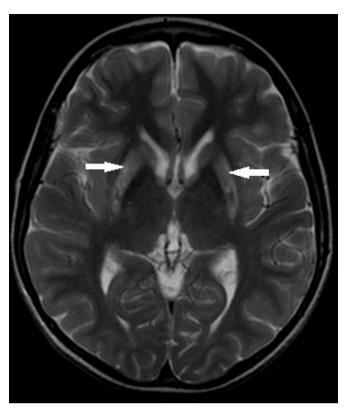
T2-weighted MRI brain image: arrow shows bilateral abnormal high signal in putamen and dark globus pallidus.
